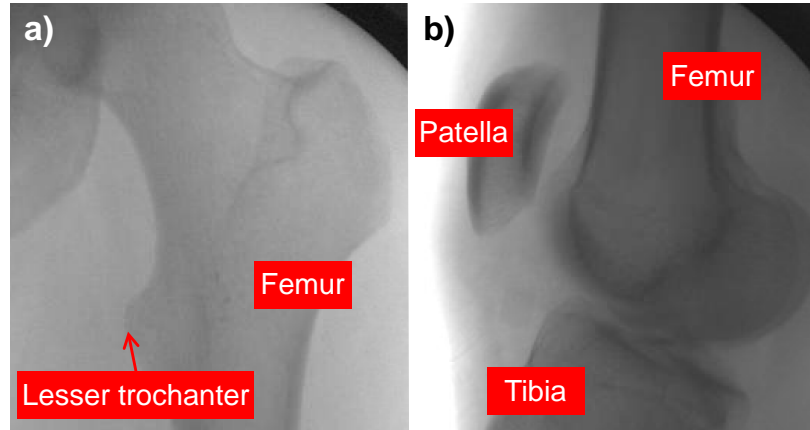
Contralateral images for guidance in rotational alignment - (a) and (b) are intraoperative fluoroscopic images from the revision surgery; AP view of the contralateral hip and lateral view of the contralateral knee. These images were utilized to guide rotational alignment of the fractured femur. By visualizing landmarks on these radiographs and understanding the change in angulation of the C-arm, the surgeon can estimate the rotational alignment of the healthy femur and attempt to recreate this alignment on the operative side.
